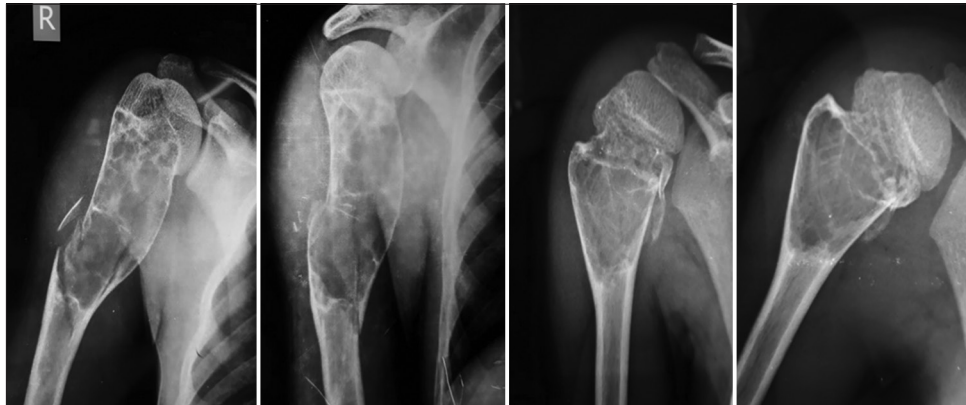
Pre- and post-X-rays of unicameral bone cyst-proximal humerus treated with intra-lesional steroid
